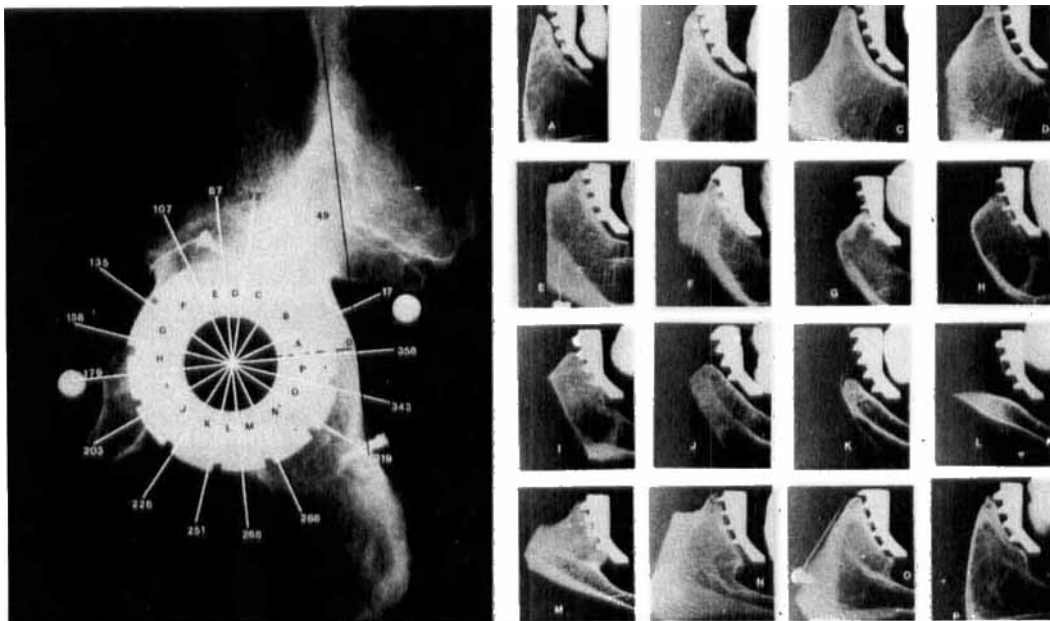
Radiograph of the left acetabulum perpendicular to the free edge of the threaded rings with 16 contact radiographs of the sections.
